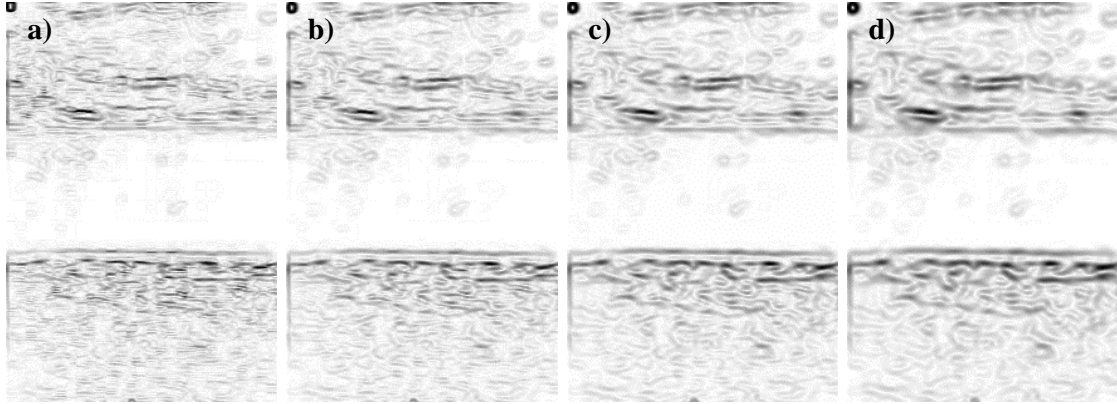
2D gradient magnitude calculated for a carotid vessel image (B-mode ultrasound) in three different scales: a) $\sigma = 0.5$; b) $\sigma = 1.0$; c) $\sigma = 1.5$; d) $\sigma = 2.0$
